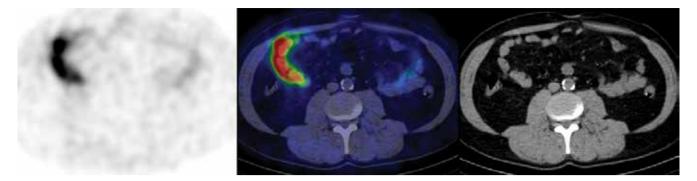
Intense physiological tracer uptake was seen in the bowel on ^{99m}Tc-Tektrotyd SPECT/CT
